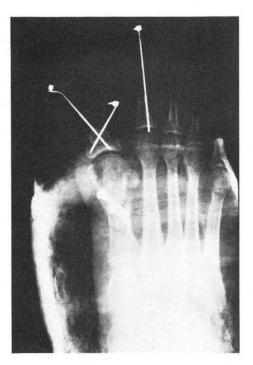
Immediate postoperative radiographs. A. Dorsoplantar view.
